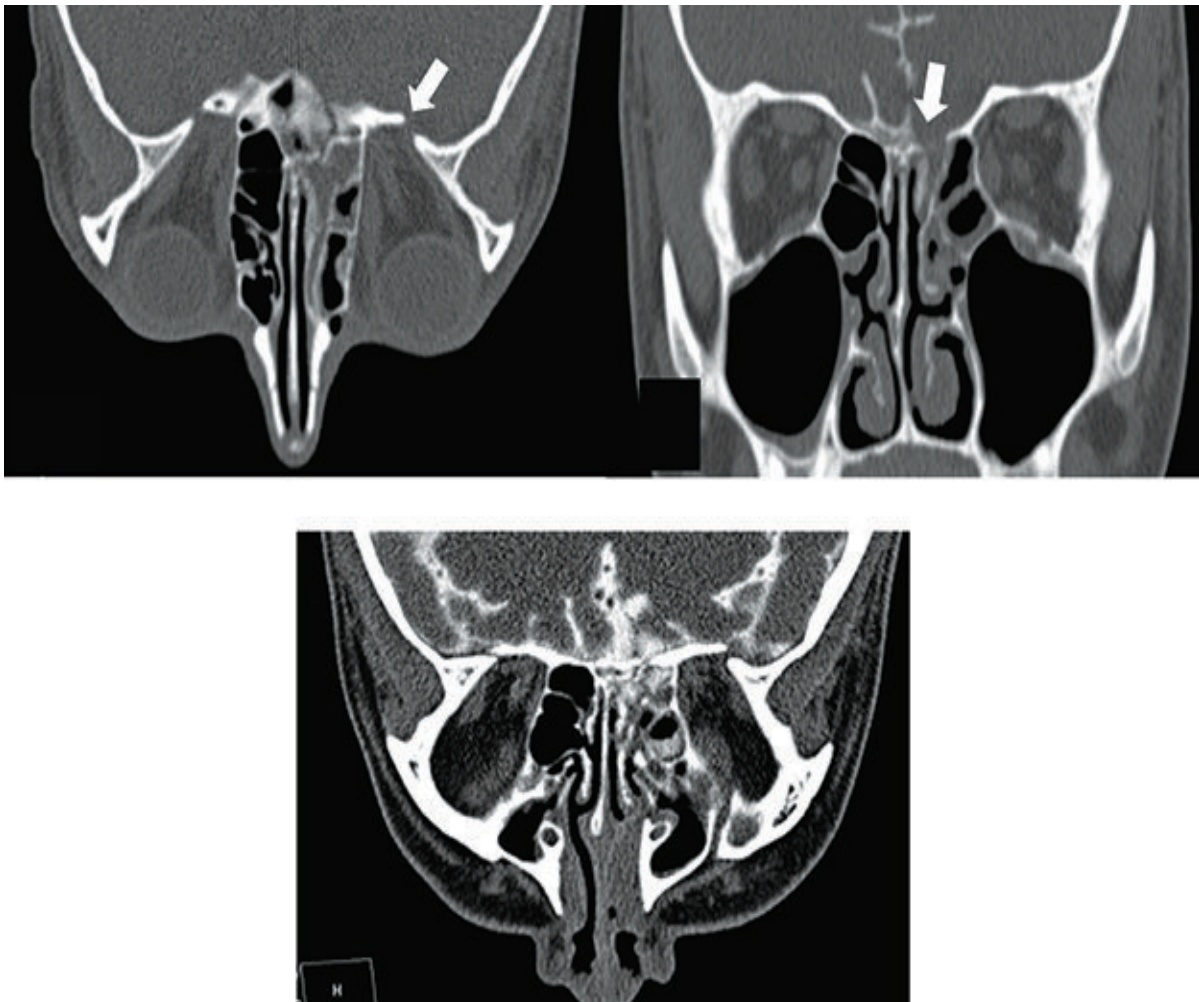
Non-contrast CT images with bone window in axial and coronal planes (A, B) demonstrate a bony defect at the roof of the left cribriform plate (white arrow). CT cisternography in the axial plane (C) shows contrast leakage into the left ethmoidal sinus.
